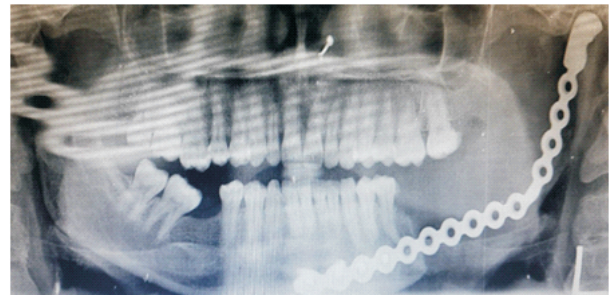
(c): 3 months Post-operative Orthopantomogram (OPG)
